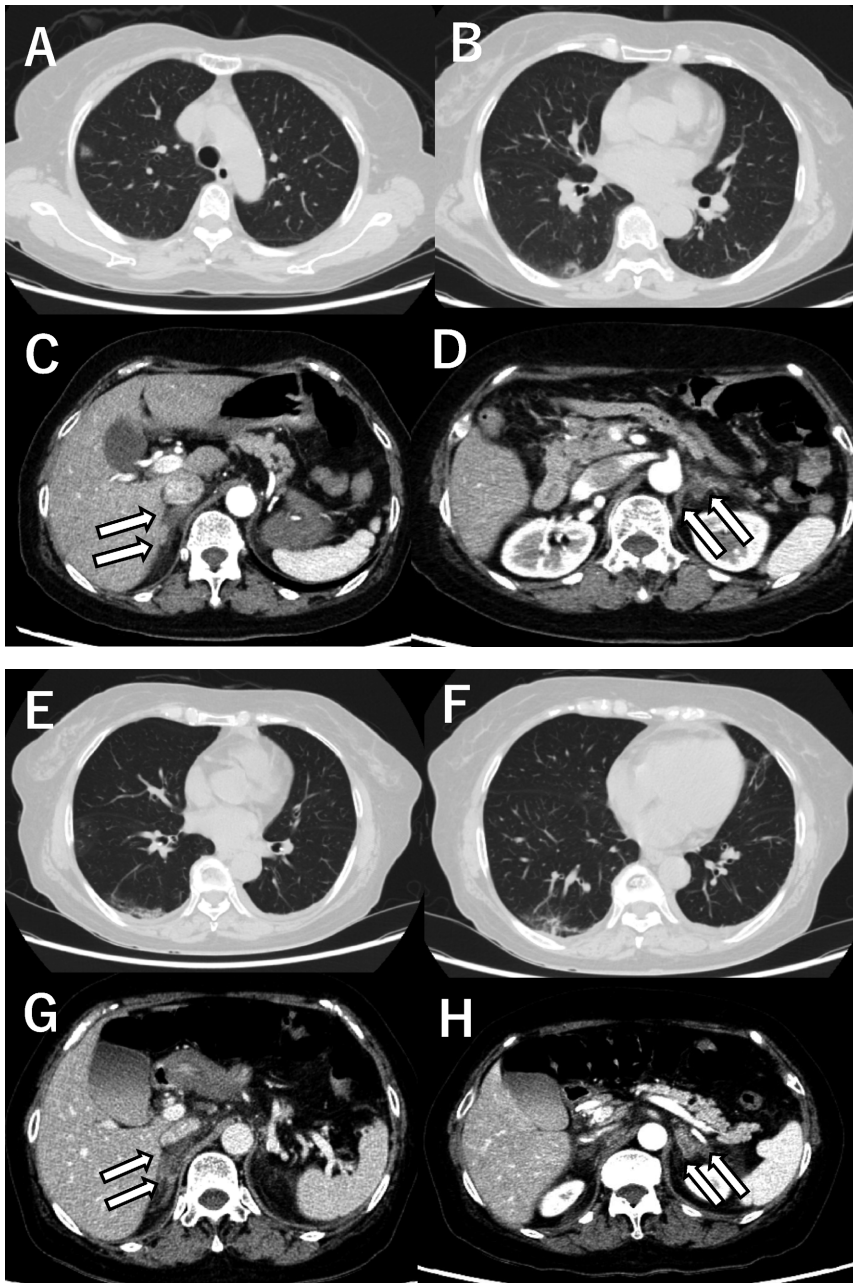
Transition of CT images with the course of the disease
